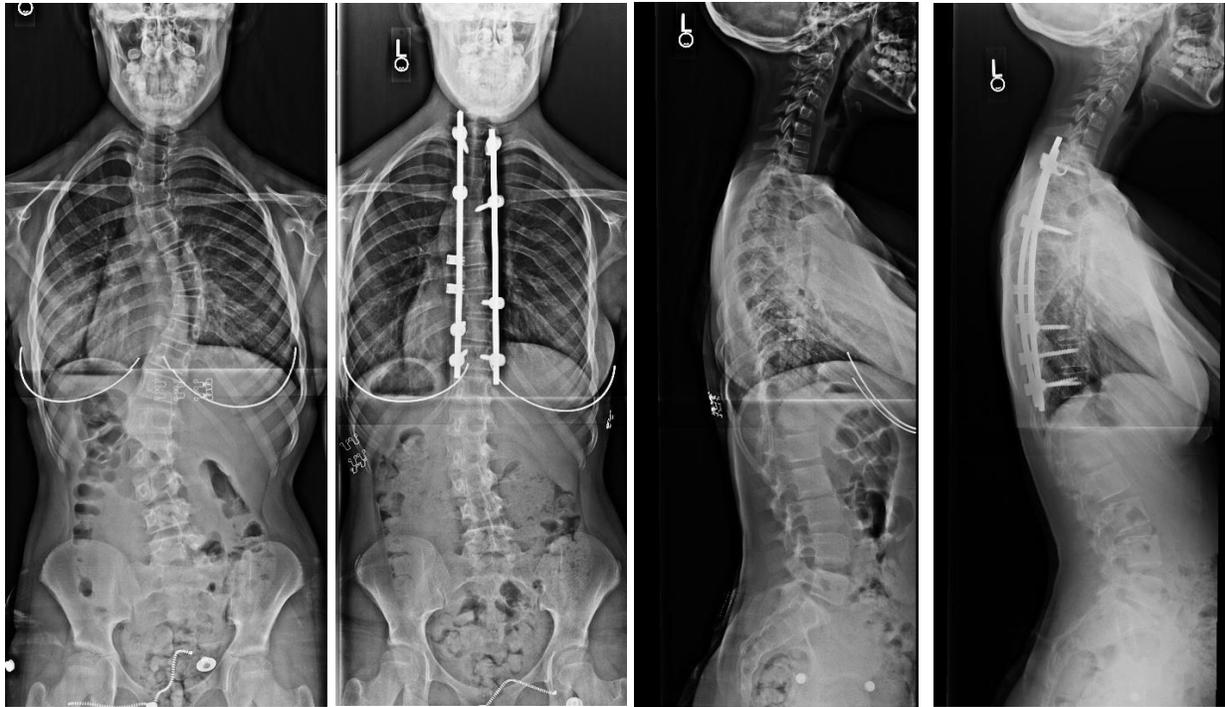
Adolescent scoliosis patient treated by Dr. Buttermann. The images on the left are pre and postoperative frontal xrays which show scoliosis correction. Sagittal images on the right show that the patient started with a lordotic thoracic spine and demonstrate recreation of a normal thoracic kyphosis with surgery.
